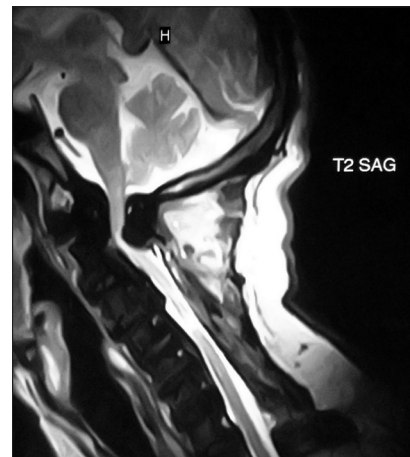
MRI cervical spine T2 sagittal images- hyperintensity in cervical cord at C1 and C2 vertebral level suggestive of compressive myelopathy
